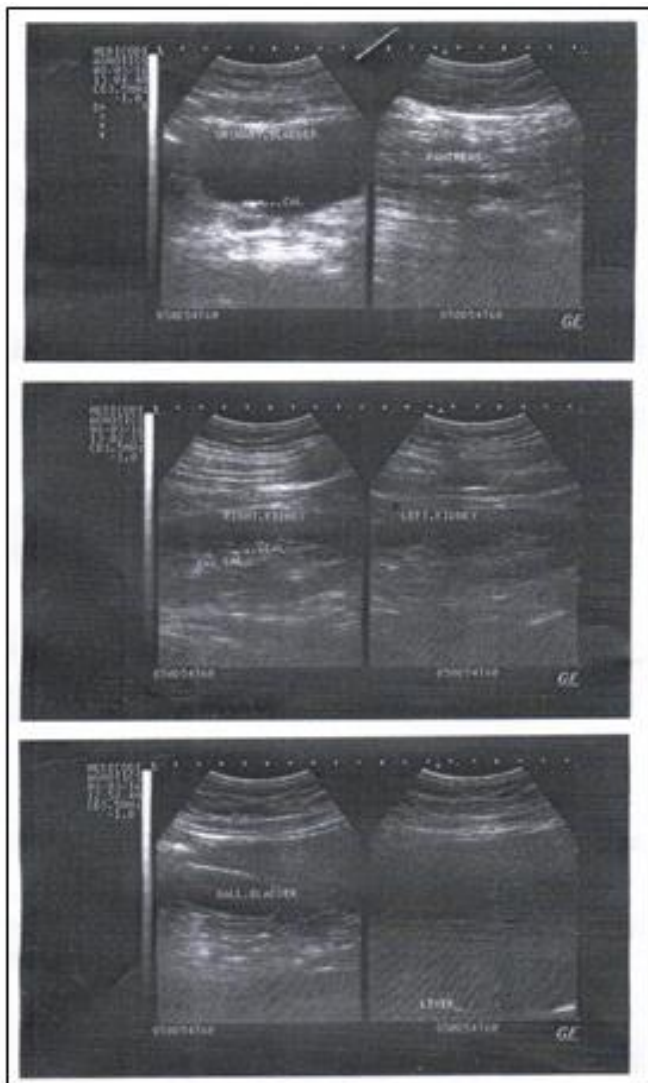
Figure 2B1: Ultrasonography Image before treatment.
